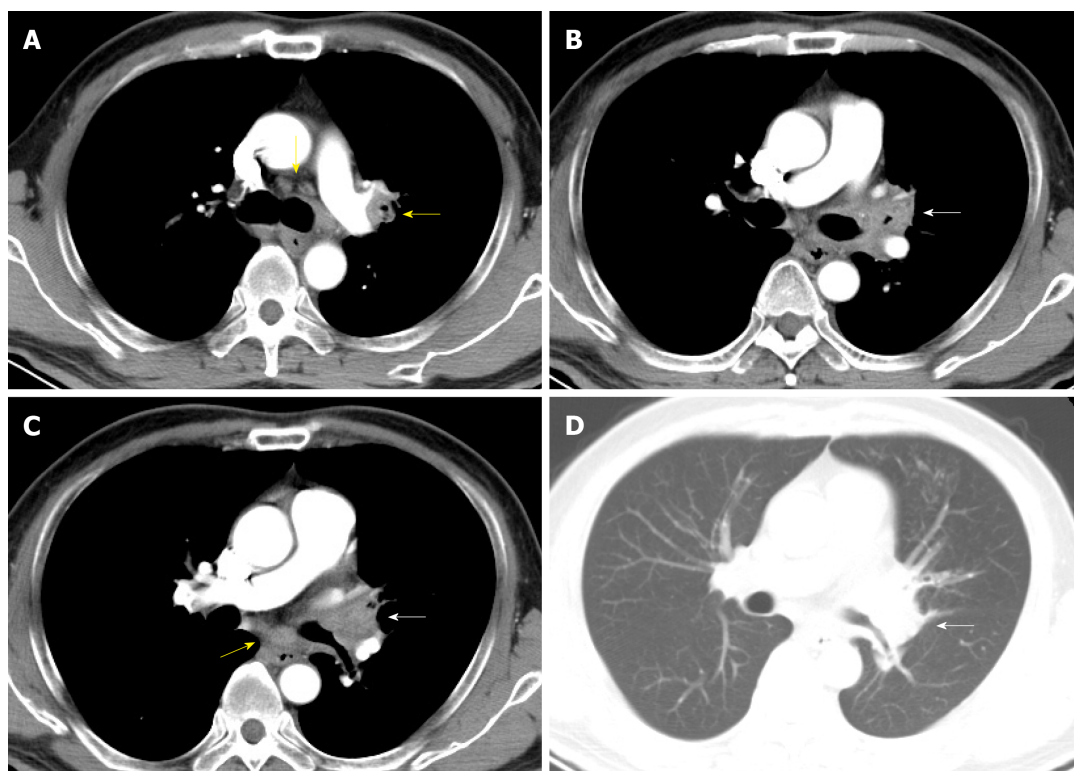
Contrast-enhanced chest computed tomography images (2018-04-07). A-C: Mediastinal window; D: Lung window. Contrast-enhanced chest computed tomography scan revealed enlarged mediastinum and hilum lymph nodes (yellow arrow) and an enlarged left hilum with a mass-like lesion leading to stenosis of the proximal part of the left upper bronchus (white arrow).
